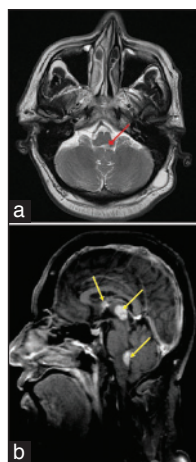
Magnetic resonance imaging (MRI) done 3 weeks into the illness showing subtle T₂ hyperintense lesion (red arrow) at the caudal end of the floor of the fourth ventricle (a) and MRI done 9 weeks into the illness showing three lesions, one at the floor of fourth ventricle, second at the mesodiencephalic junction, and third at the fornix (b). Yellow arrows point to the lesions
